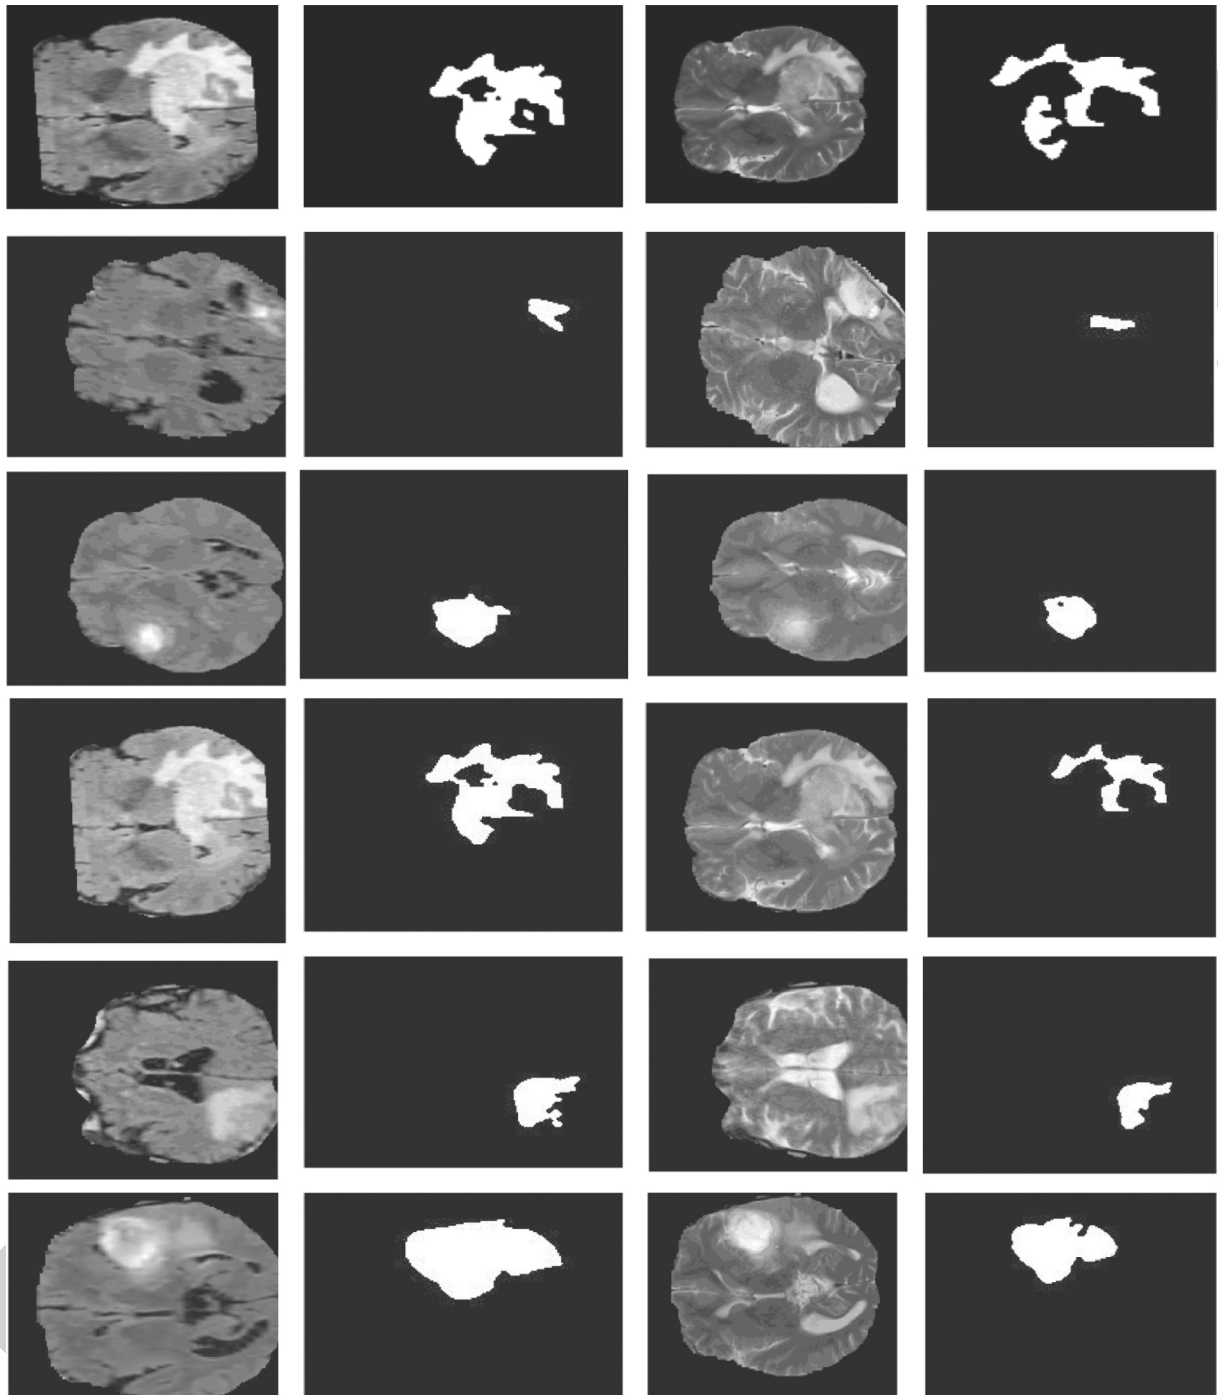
Result of the proposed segmentation in FLAIR and T2 images.
